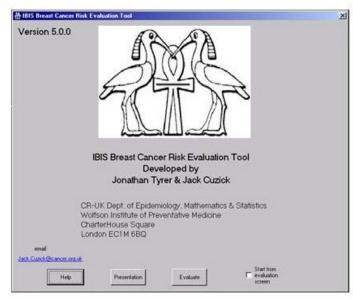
Algorithm for assessing breast cancer risk: making decisions about referral to genetic services and ordering breast MRI screening for women.
